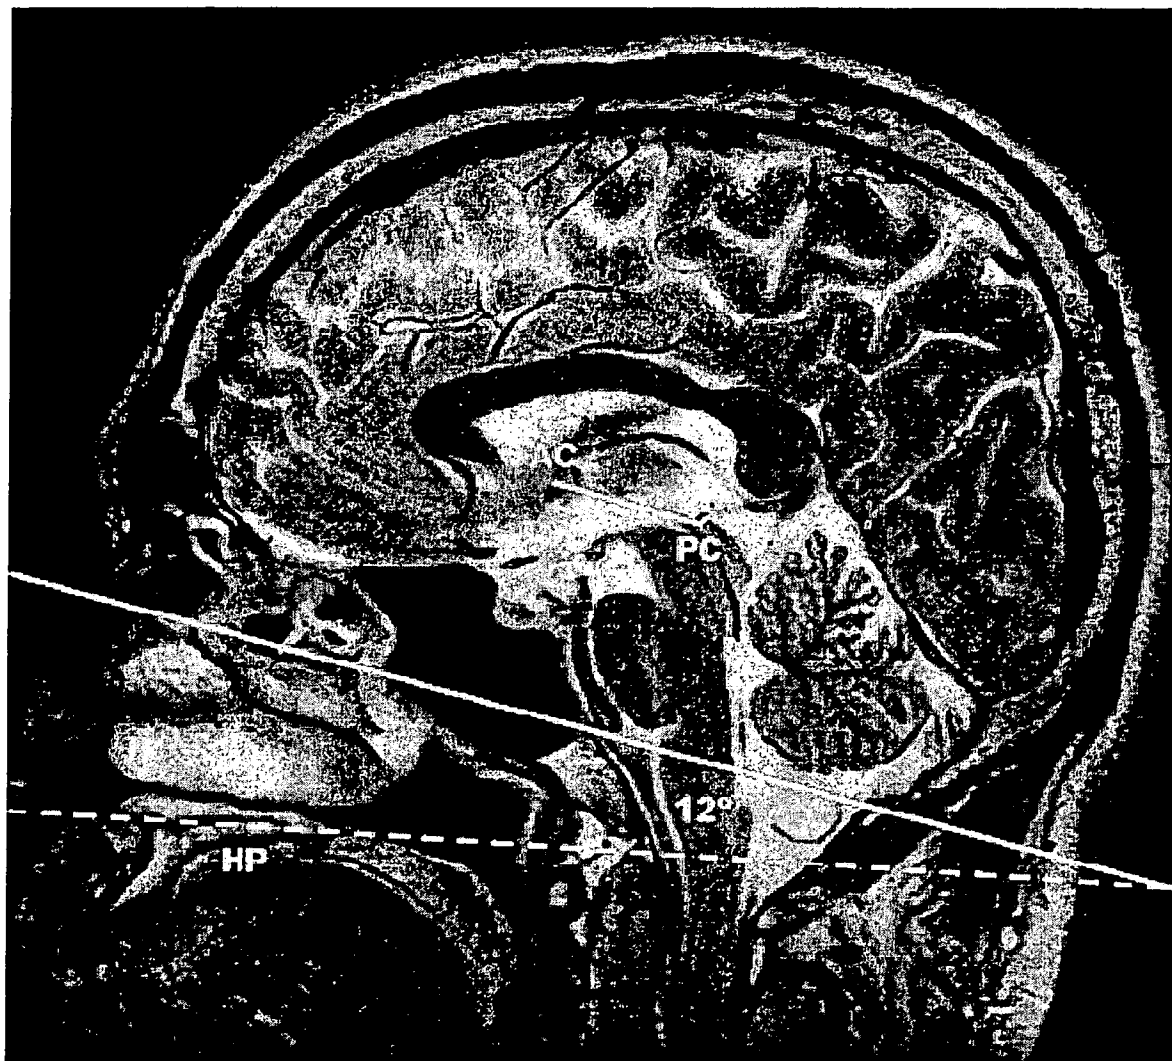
Midline roll- and yaw-corrected sagittal fast spin-echo T2-weighted MR image (TR/TE, 3816/105_{eff}; echo train length, 16; section thickness, 4 mm; matrix 512 × 256; field of view, 20 cm). The short solid line corresponds to the Talairach AC-PC basal reference; The long solid line is drawn parallel to the Talairach AC-PC reference, and the dashed line passes through the superior cortical surface of the hard palate. Note in this prototypical case the angle subtended by the Talairach AC-PC line and the hard palate is 12°. AC, anterior commissure; PC, posterior commissure; HP, hard palate.
